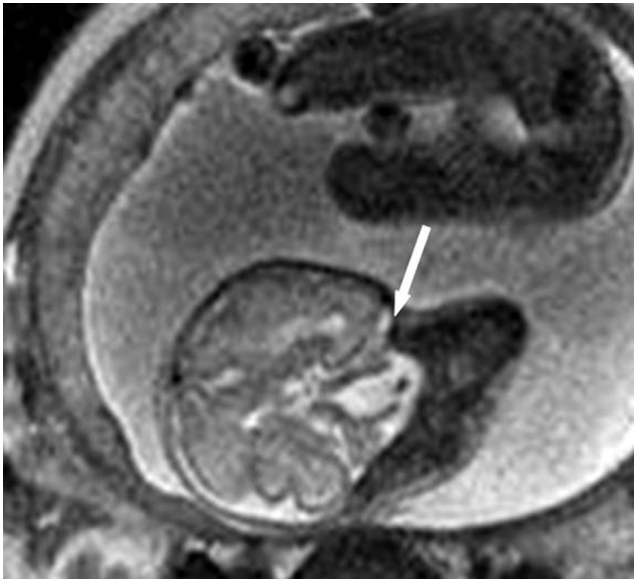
MR image reveals the short fetal neck, hyper-extended cervical spine (straight arrow) and upturned face (curved arrow) of fetus II.
